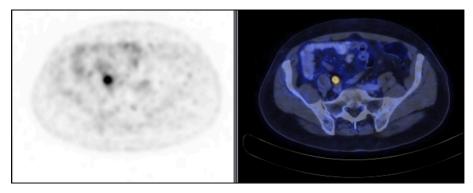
Axial slice of <sup>68</sup>Ga-PSMA-PET/CT imaging showing thickening of the right ureteric wall in conjunction with increased PSMA avidity (SUV<sub>max</sub> 7.6).
